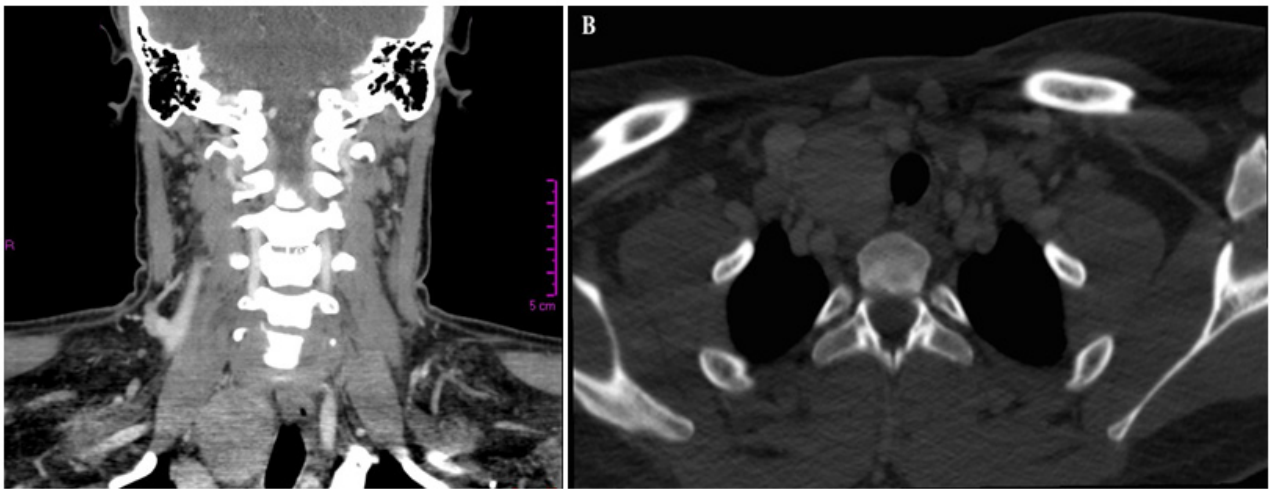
Chest CT scan with evident solid heterogeneous enhancing mass of approximately 3.5 cm in largest axial diameter localized inferior to the right thyroid lobe extending through the thoracic inlet.
